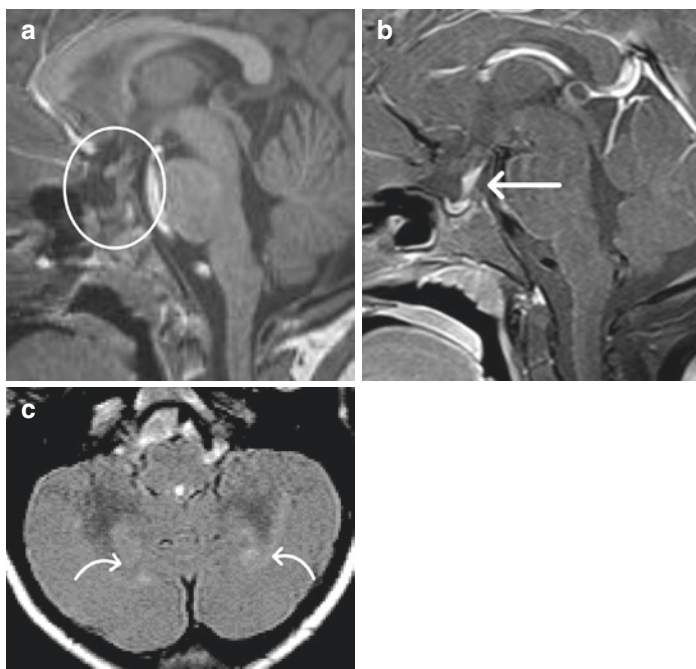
Langerhans' cell histiocytosis (LCH) MRI images of a 9-year-old boy with LCH. (a) Unenhanced T1 sagittal image showing absence of the normal posterior pituitary bright spot. (b) Postcontrast sagittal T1 with fat saturation demonstrate thickened enhancing pituitary stalk (straight white arrow). (c) Axial FLAIR shows hyperintense lesions in the cerebellum (curved arrows)
